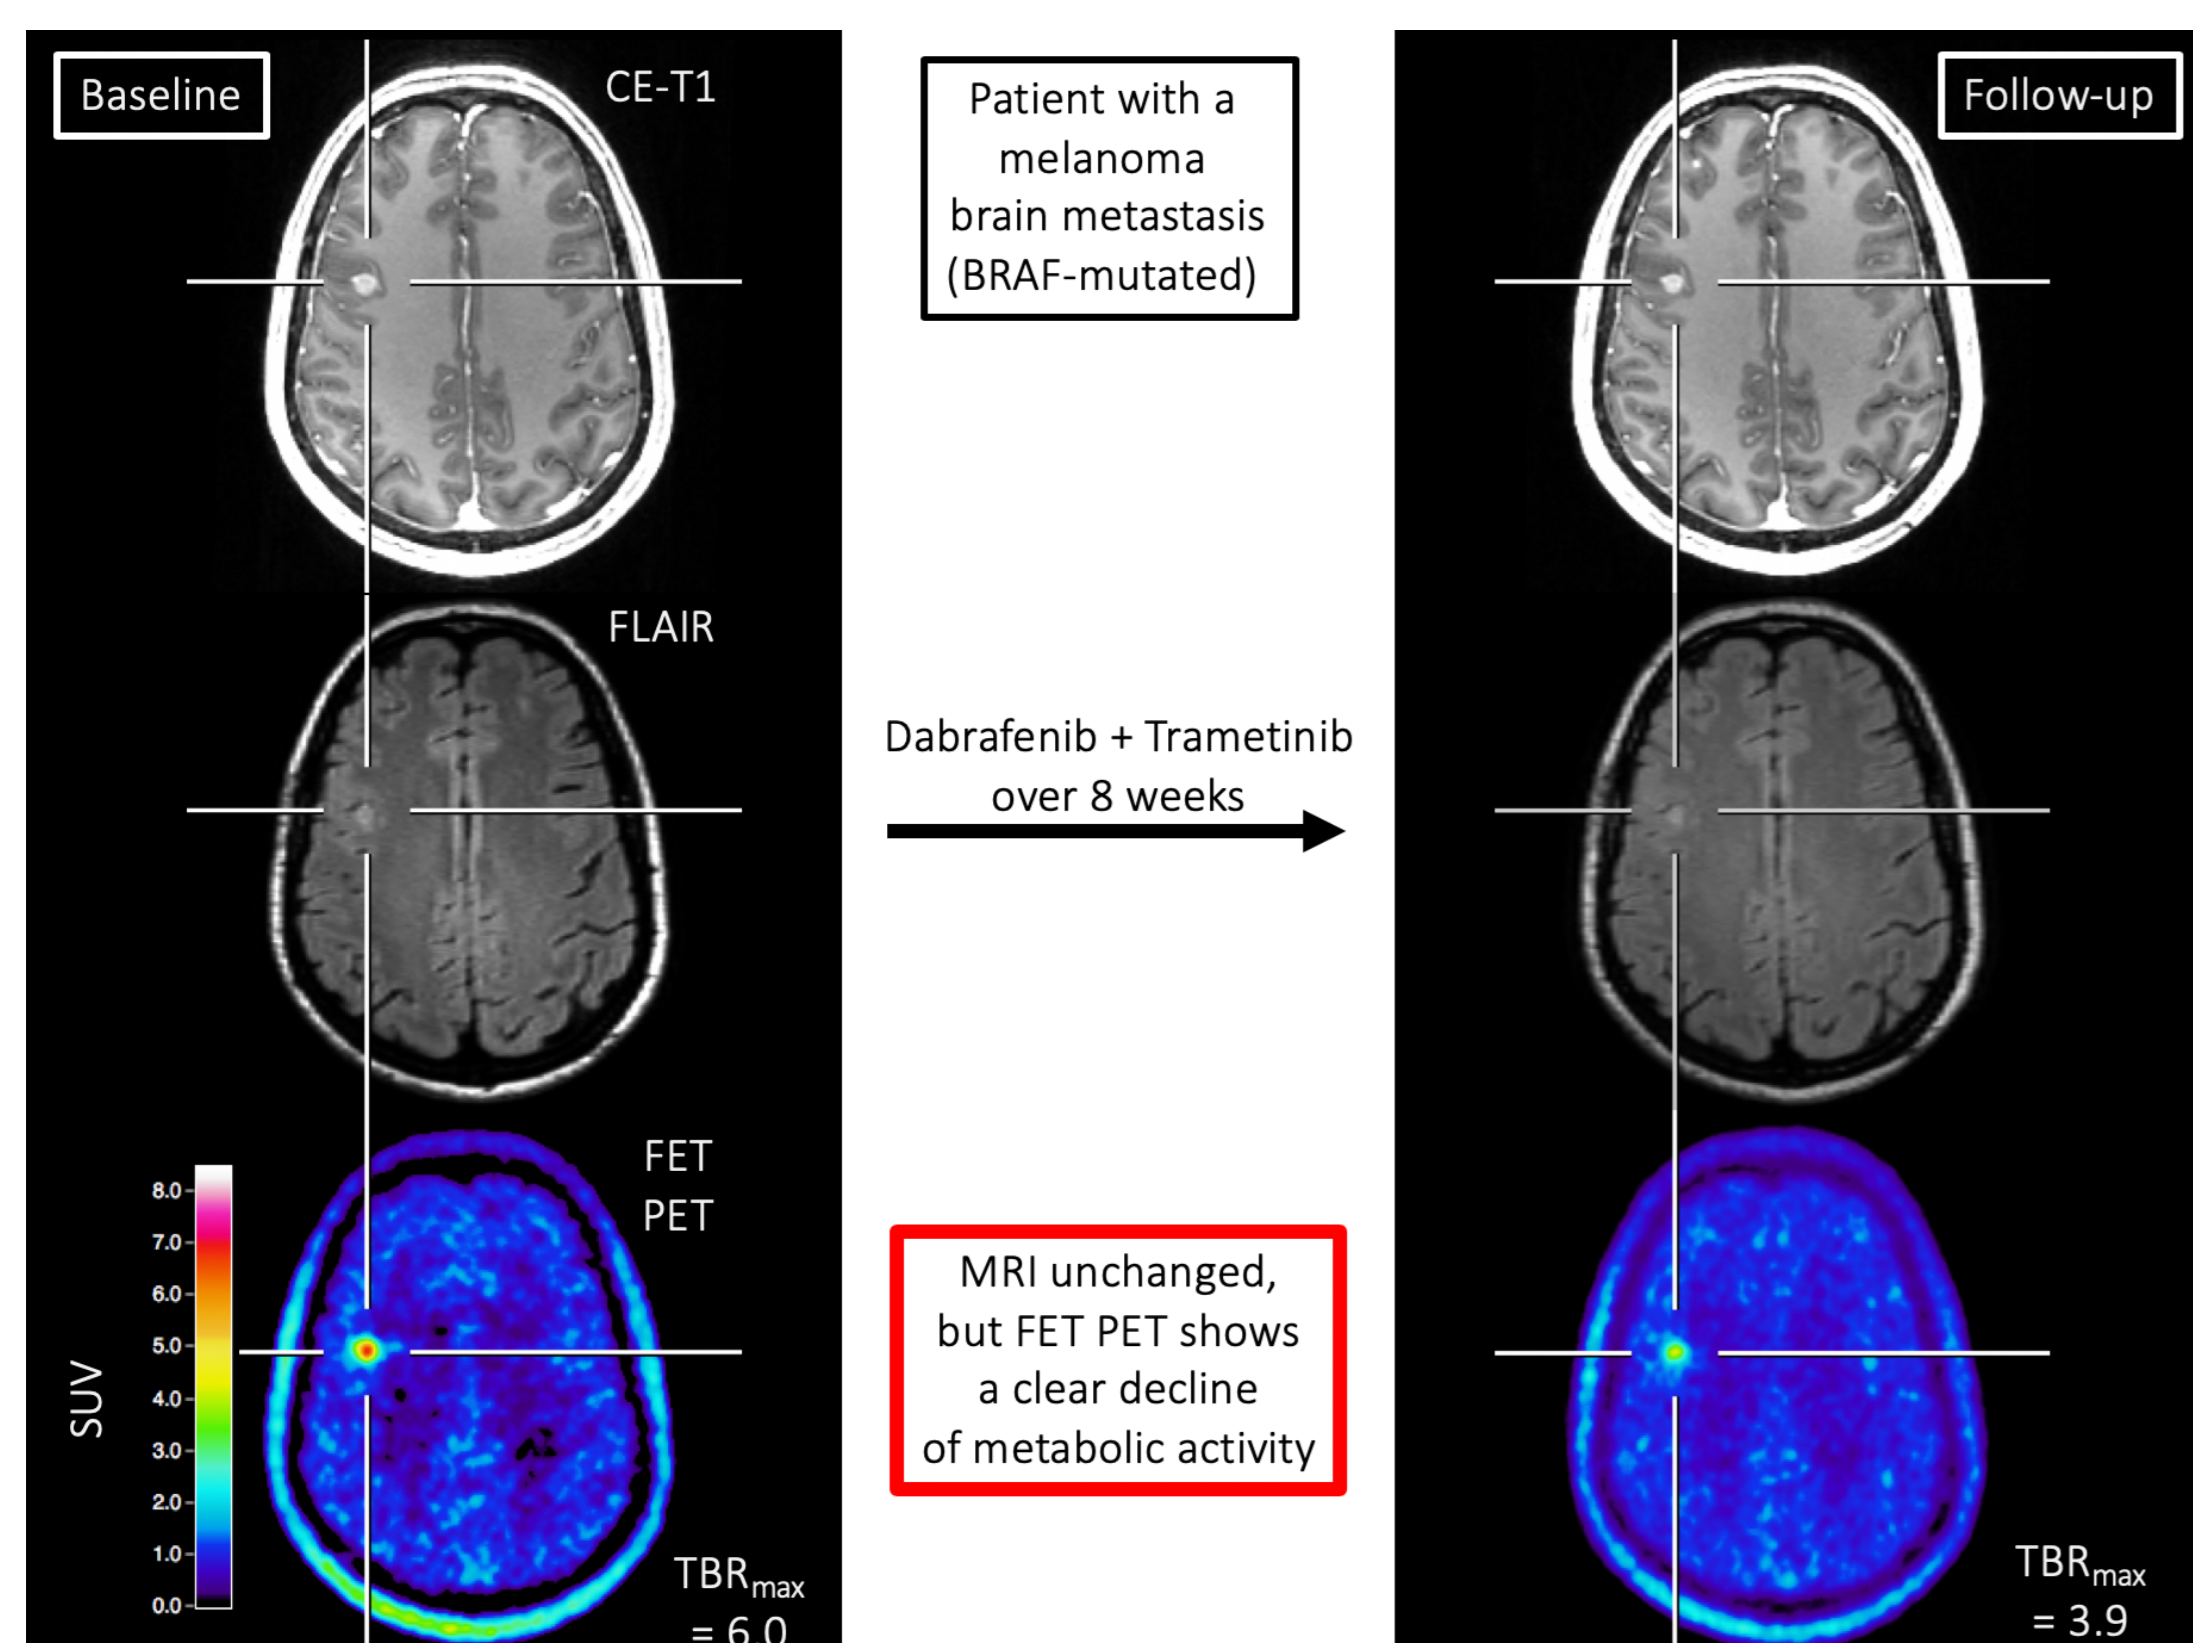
Baseline and follow-up images of patient with a melanoma brain metastasis. At follow-up, a clear decrease of the tumor/brain ratios (-35%) is observed whereas the MRI shows no significant change of both the contrast enhancement and FLAIR signal defined as stable disease according to RANO criteria for brain metastases
